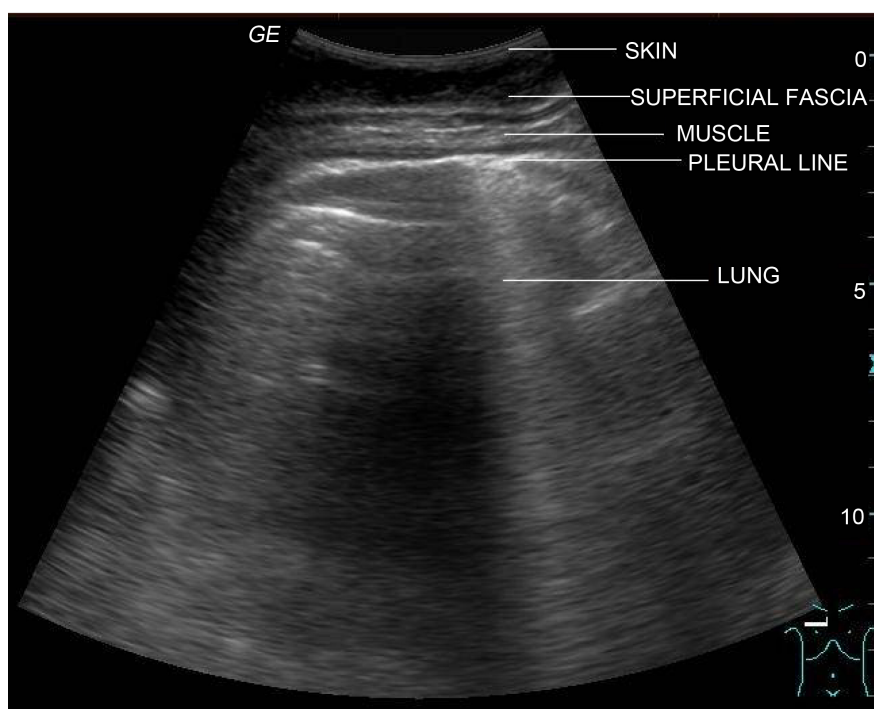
Normal sonographic appearance of chest wall.
